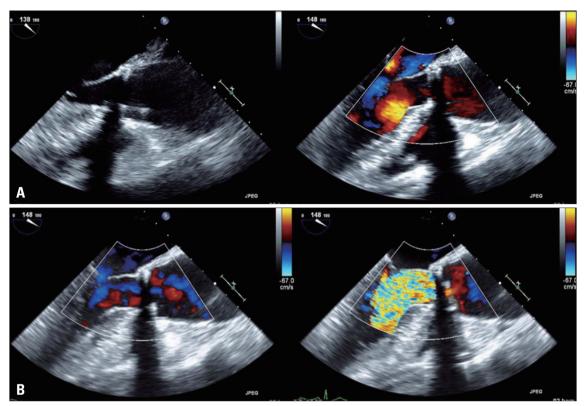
Transesophageal echocardiography showed normal systolic excursion of the occluding disk (A) and color Doppler revealed intermittent non cyclic severe acute aortic valve regurgitation (B).
